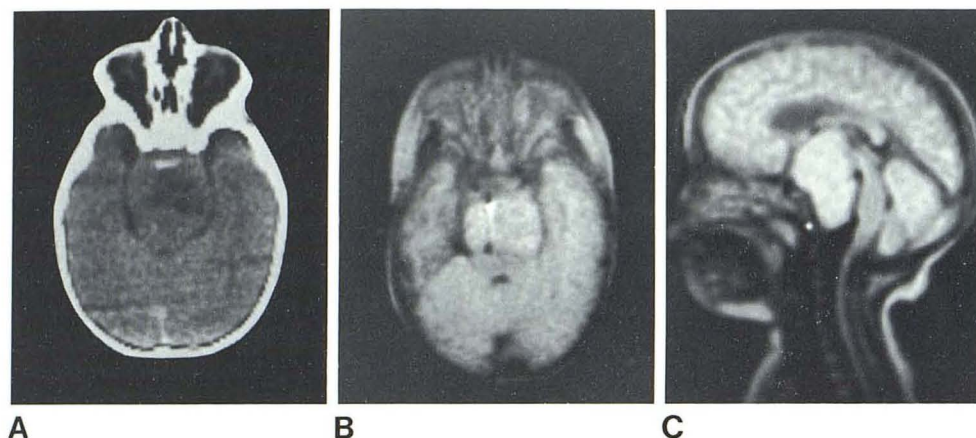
Hypothalamic hamartoma extending into posterior fossa. A, Contrast-enhanced CT scan. Transverse (B) and sagittal (C) SE<sub>1000/80</sub> NMR scans. Extrinsic lesion causes posterior displacement of brainstem.
